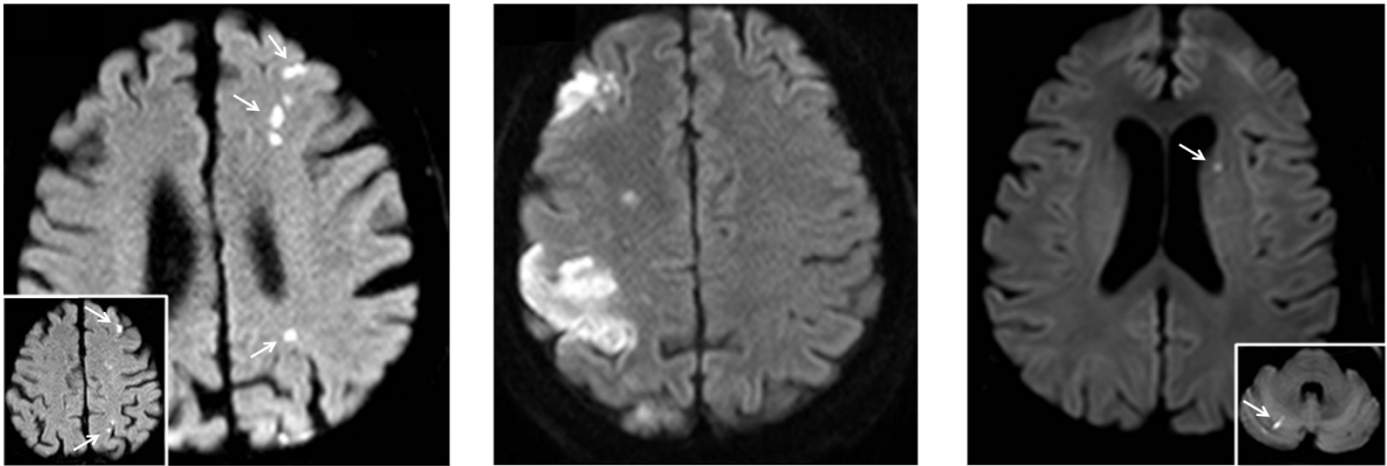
Brain MRI patterns in patients with acute CRAO can help identify source of emboli
